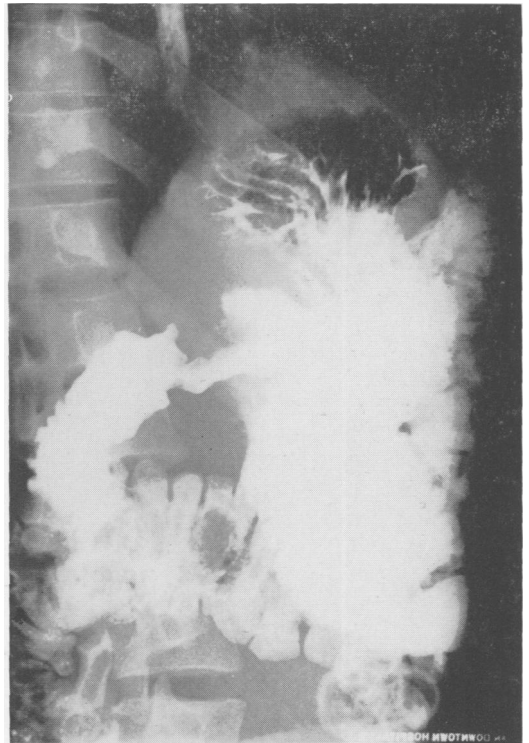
Roentgenogram of the stomach. There is a filling defect in the antrum with rigidity of the wall. Note outline of a polyp in the transverse colon by residual barium.
